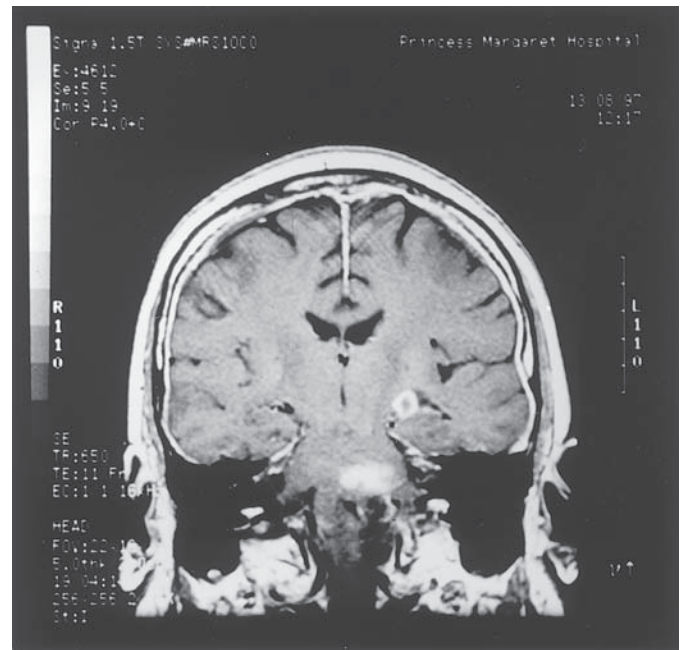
A T1-weighted MR scan with gadolinium contrast shows two parenchymal lesions and diffuse thickening and enhancement of the cerebral leptomeninges. This man developed severe headaches 15 yr after receiving radiotherapy for a pituitary adenoma. An initial MR scan showed only abnormal meningeal enhancement. Meningeal biopsy revealed clumps of neoplastic astrocytes, and a subsequent MR scan confirmed the presence of an underlying high grade glioma, presumably radiation-induced.
